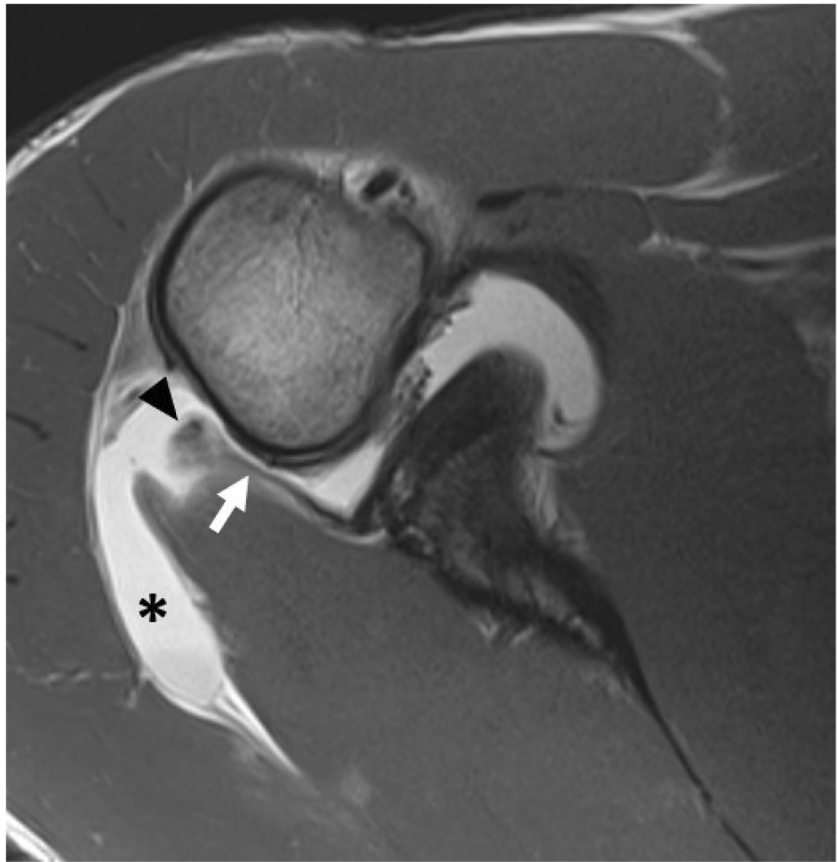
Axial T2 fat-saturated MR image demonstrates a full-thickness tear of the posterior band of the inferior glenohumeral ligament from its humeral attachment (arrow) with associated extracapsular joint fluid along the PIGHL (arrowhead) consistent with a posterior humeral avulsion of the inferior glenohumeral ligament
